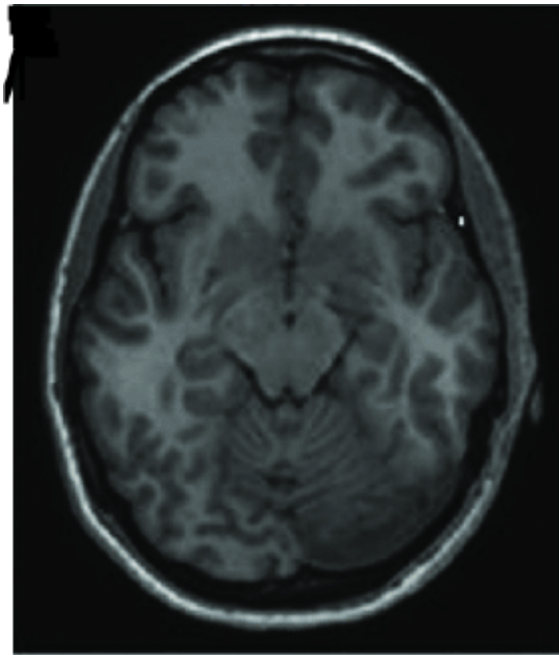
An example of an MRI scan
